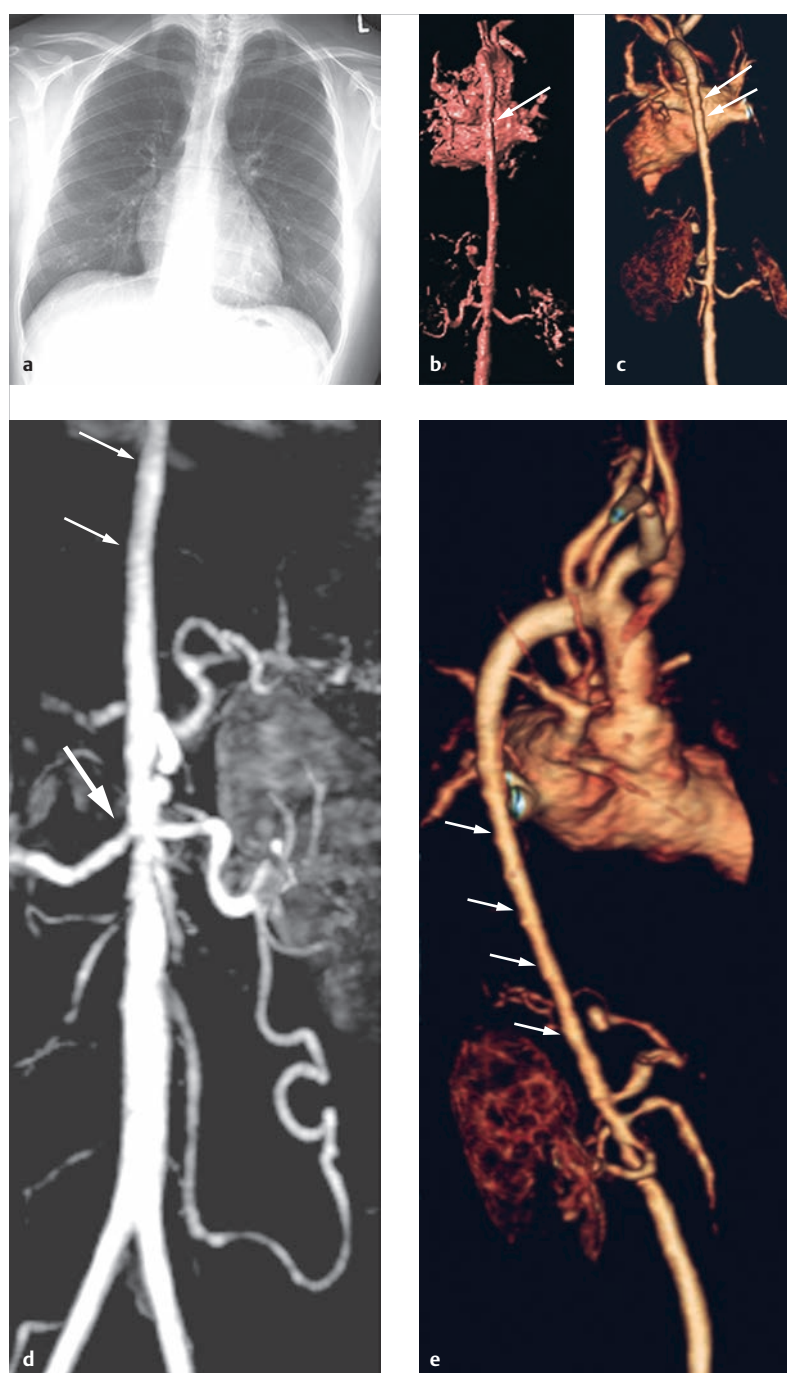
Hypoplastic descending aorta in a case of Williams-Beuren syndrome. Nineteen-year-old male patient. The p.-a. thoracic X-ray (a) for initial diagnosis depicts a narrow superior mediastinum. The initial images using volume rendering technique and 3-D MIP reconstruction from a contrast-enhanced MRA depict several mid-grade renal origin stenoses, in addition to the extended hypoplastic descending aorta (b–d, arrows). The follow-up examination 4 years later (e) depicts primarily unchanged findings for the descending aorta and regression of the renal origin stenosis on the right side.
